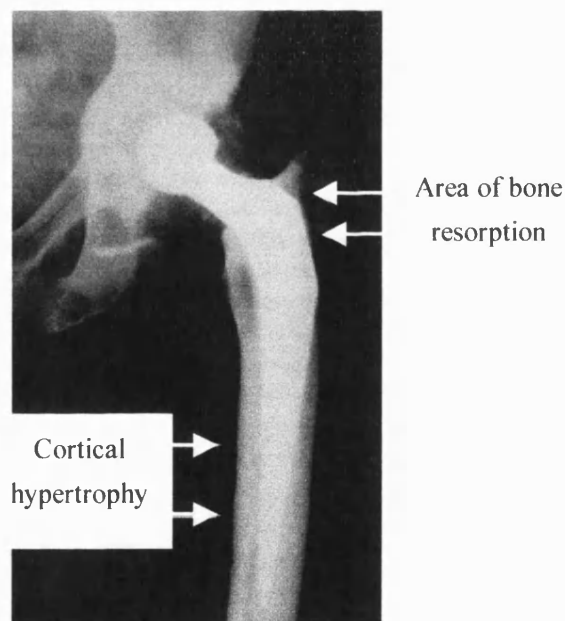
Radiograph showing results of long-term remodelling (Bannister 1993)
